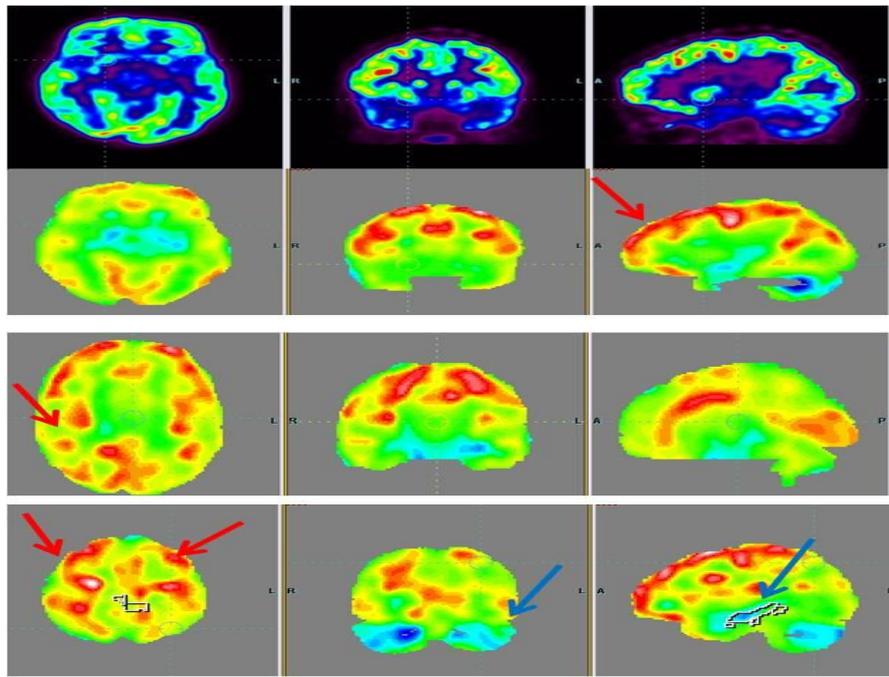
18FDG PET in a 8 years old boy with autism shows reduced FDG uptake (blue arrows) in mesial temporal structures like amygdala, hippocampus and cerebellum while increase in uptake in anterior, middle and posterior cingulate gyri and frontal and occipital I.
